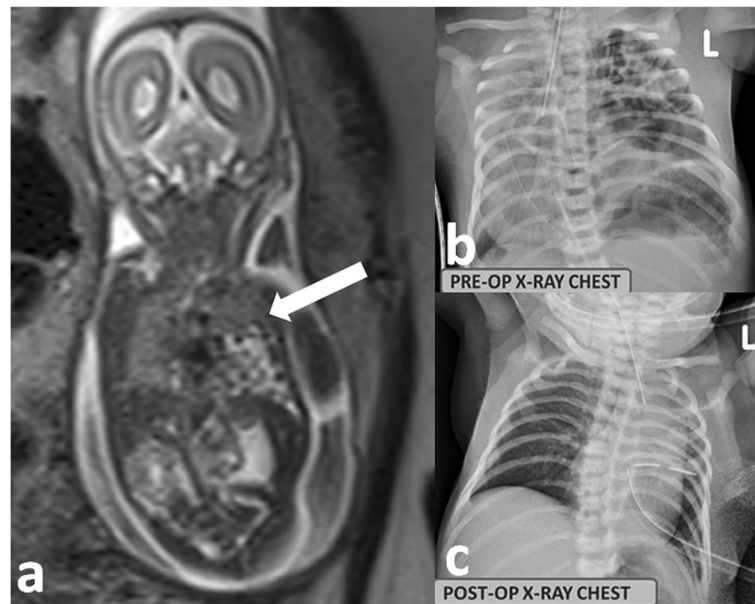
Twenty-eight-year-old G2 P1 L1 at 21 weeks of gestation with features of left-sided diaphragmatic hernia. a Coronal T2-weighted MRI image of the fetal trunk showing the presence of stomach and small and large bowel loops in the thoracic cavity (arrow) with no discernible hypointense line between the left lung and abdominal viscera. b Postnatal chest radiograph taken on the 1st day of life showing multiple bowel loops in the left hemithorax with complete mediastinal shift to the right side. Endotracheal tube is noted in situ in the trachea which is deviated to the right side. The baby underwent diaphragm repair surgery. c Post-operative chest radiograph showing normal position of both domes of diaphragm with endotracheal tube and left intercostal drainage tube in situ
